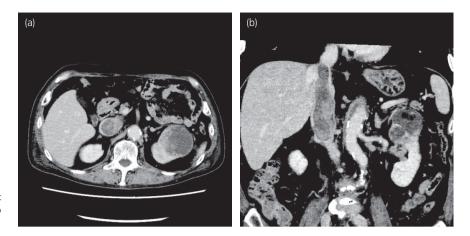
Enhanced computed tomography. (a) Left renal tumor. (b) Thrombus extending into the IVC to above the hepatic vein but not to the diaphragm.
